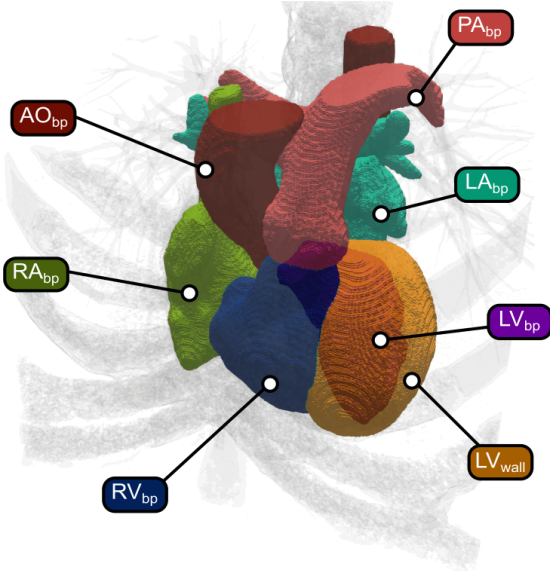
Multi-label segmentation from CT image with seven labels representing blood pools of LV, RV, LA, RA, AO, and PA as well as the LV myocardial wall.
